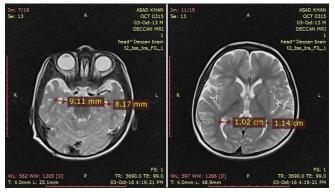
Magnetic resonance imaging of 1 yr old boy showing temporal and occipital horn horizontal diameter
